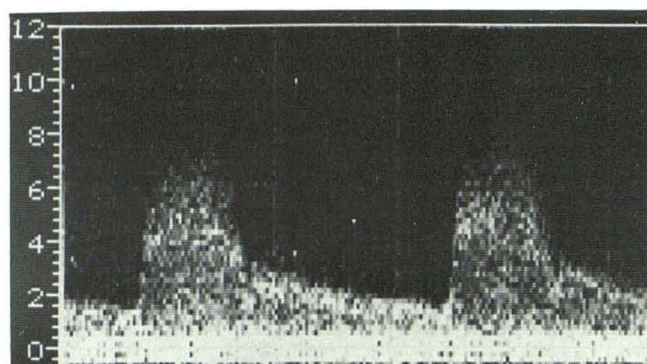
Underestimation of stenosis* in 59-year-old man with transient ischemic episodes. Carotid Doppler study was interpreted as nonhemodynamically significant stenosis of right internal carotid. A, Review of Doppler findings demonstrated considerable elevation of peak systolic frequency in stenotic zone and extension of high velocity flow into diastole (*arrowheads*). Poststenotic turbulence (not shown) was also evident. B, Arteriogram. Major stenosis was underestimated on original Doppler interpretation.
